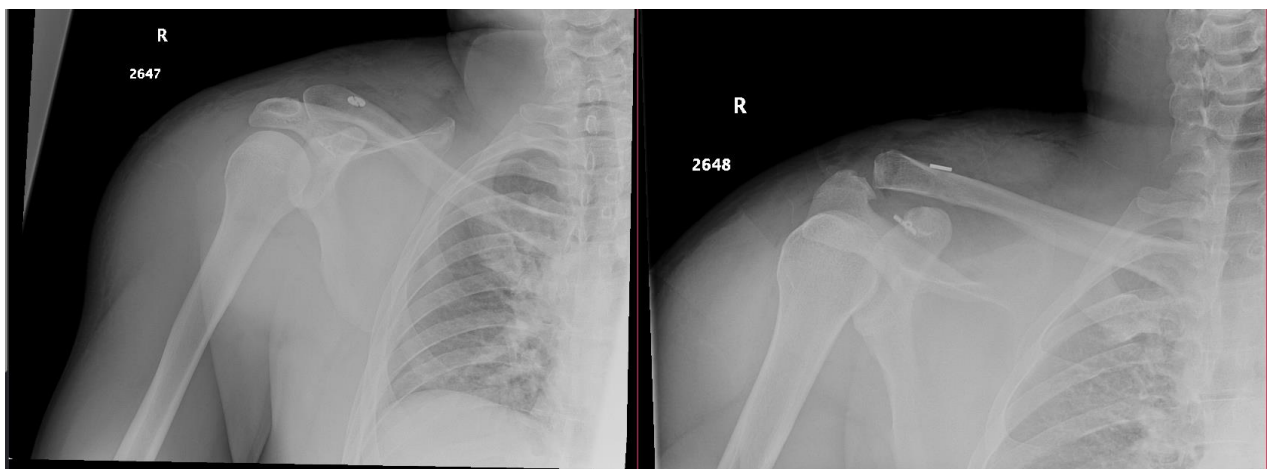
10.07.2021 X-Ray Right Shoulder
